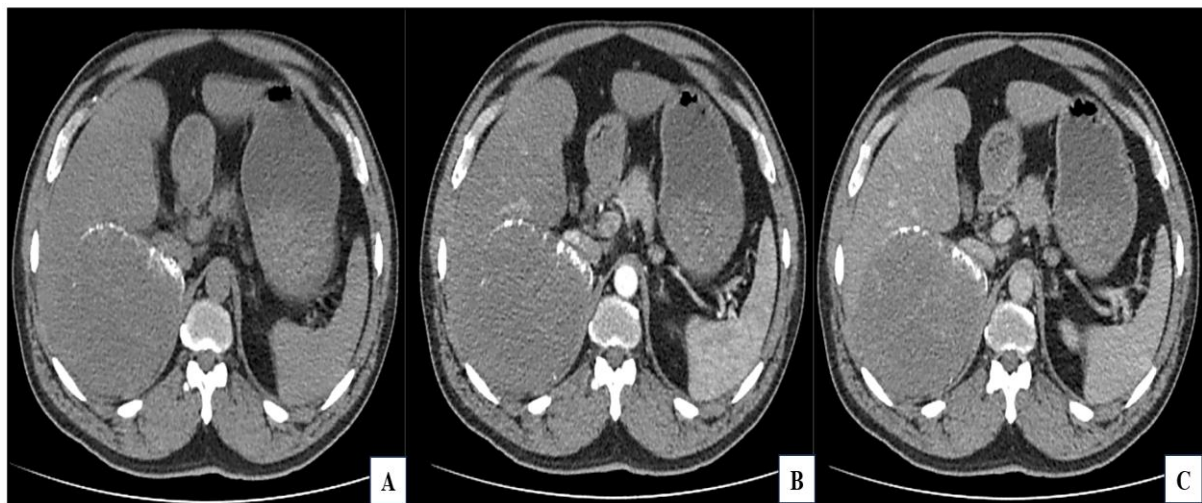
CT Urogram: Well-defined soft tissue density lesion measuring 14x11x10.7cm with calcifications in the right adrenal gland
